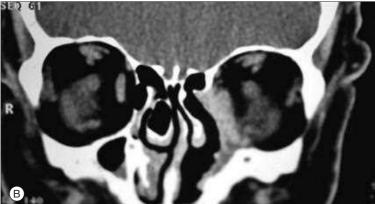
(A) A 65-year-old man with several years of progressive diplopia, left epiphora, and a sunken appearance at the left medial canthus with a hard medial palpable mass. (B) A coronal CT scan shows a mass in the medial orbit involving the medial rectus muscle and the lacrimal drainage apparatus. There is loss of bone in the medial orbital wall and adjacent turbinates and ethmoid sinuses. He has a limited form of granulomatosis with polyangiitis, and is ANCA negative.
